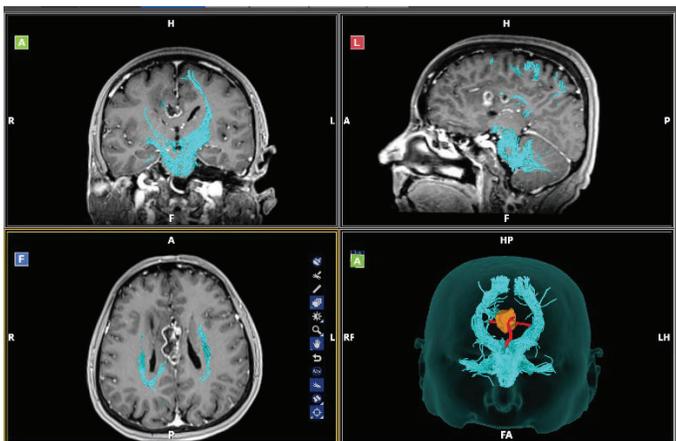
Pre-op MRI with tumor segmentation and tractography overlay.
